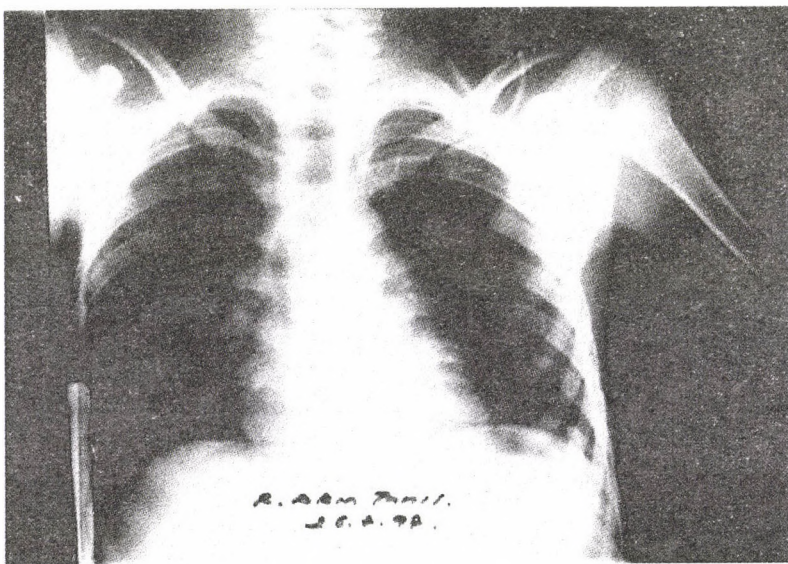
Chest radiograph of the same patient after the tube was removed
